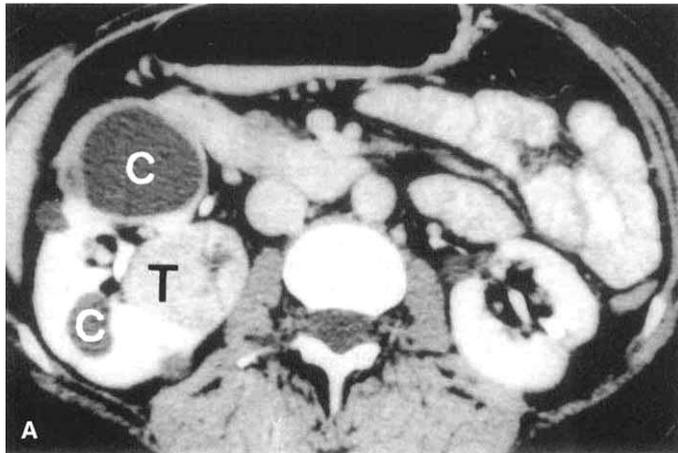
Asymptomatic bilateral renal cysts (C) and renal carcinoma (T) in von Hippel-Lindau disease, abdominal CT scan at two levels (A and B) with intravenous contrast from a 45-year-old female.
